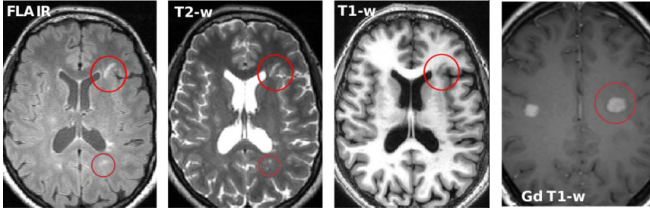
T2-FLAIR, T1-w, T2-w and Gd T1-w images of brain damage. MS lesions are indicated by red circles.
